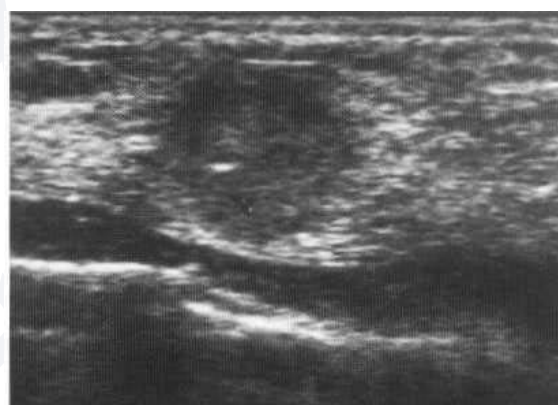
Ultrasound of a 48-year-old woman with a palpable left breast mass. The mammogram did not demonstrate a mass. Ultrasound shows a solid mass. FNAC - malignant cells. Final diagnosis - invasive breast carcinoma.
